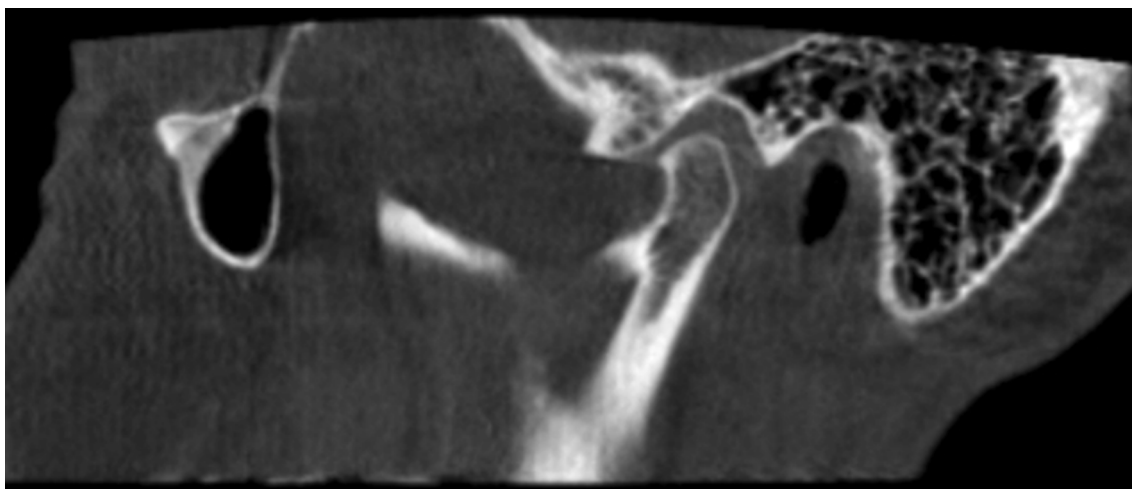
Female, 69 years. Oblique sagittal CBCT view shows small beaking of the anterior aspect of the condyle due to the close position of the cortical plates, interpreted as no osteoarthritis. CBCT, cone beam CT.
